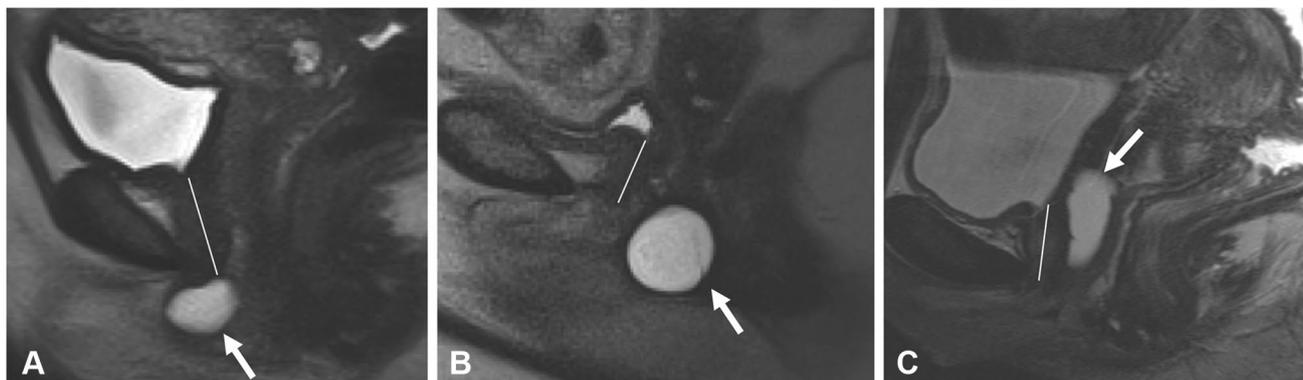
Urethral/periurethral cysts can be diagnosed based on location. Sagittal T2-weighted images from three different patients reveal a Skene's gland cyst (a), Bartholin gland cyst (b), and Gartner duct cyst (c). a The Skene's gland cyst (arrow) is centered on the distal urethra, and located within the plane of the urethra (white line). b The
